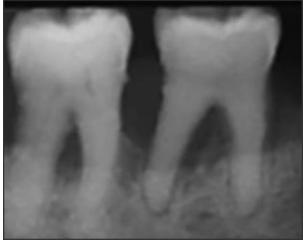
Periapical radiograph of pulpal sclerosis with total obliteration of pulp structures of mandibular right molar, #30.
